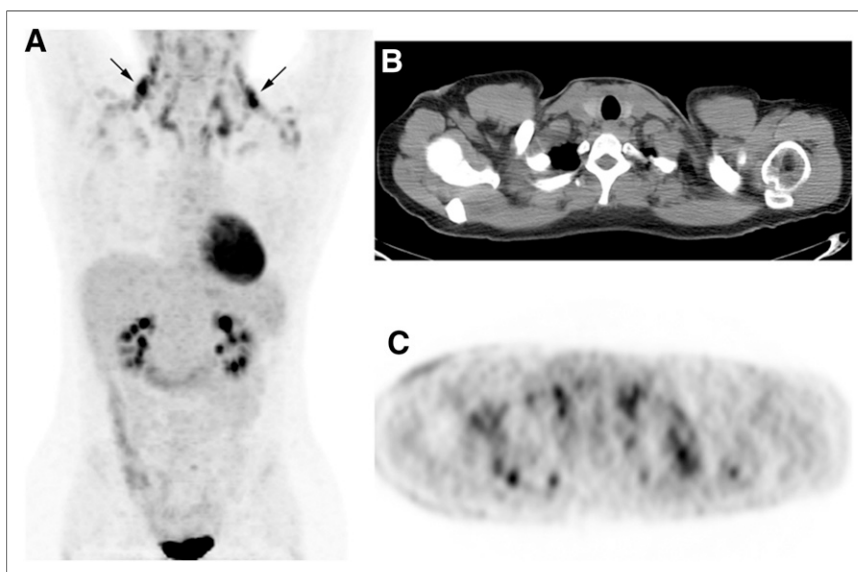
(A) Maximum-intensity-projection image shows intense bilateral radiotracer activity (arrows) in cervical and supraclavicular regions secondary to activation of BAT. (B and C) Axial non-contrast-enhanced CT (B) and PET (C) images localize radiotracer activity to cervical adipose tissue.
